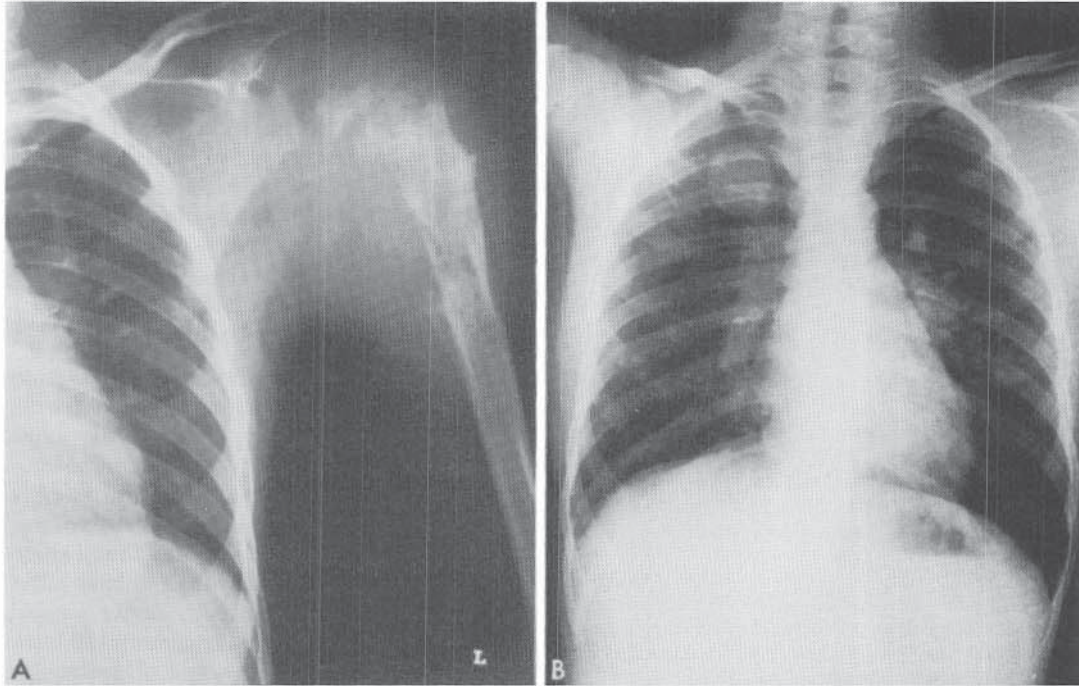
Osteogenic sarcoma of the left proximal humerus in a 12-year-old boy. The patient complained of pain in the left arm and shoulder of 1 month's duration. A, Radiograph of the left humerus showing the malignant lesion. B, Chest radiograph showing metastasis in the right upper lobe.
